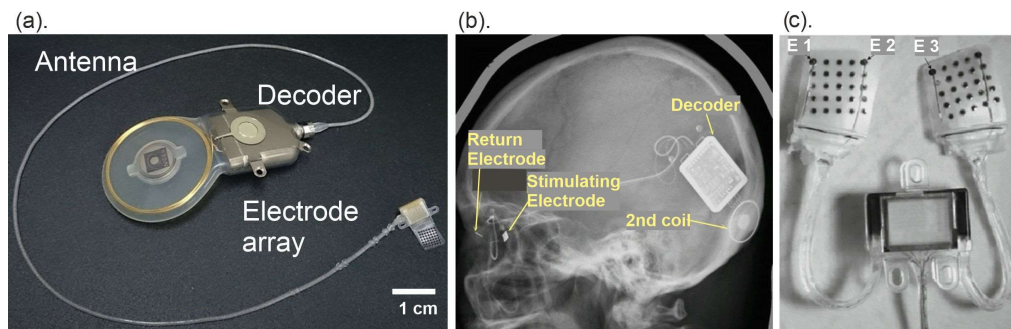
Suprachoroidal-Transretinal Stimulation device from Osaka University. (a) The components which are surgically implanted within the STS system; (b) A lateral X-ray projection taken after implantation; (c). A closer view of the 49-channel stimulating electrode array. Image courtesy Fujikado et al. 2016.
